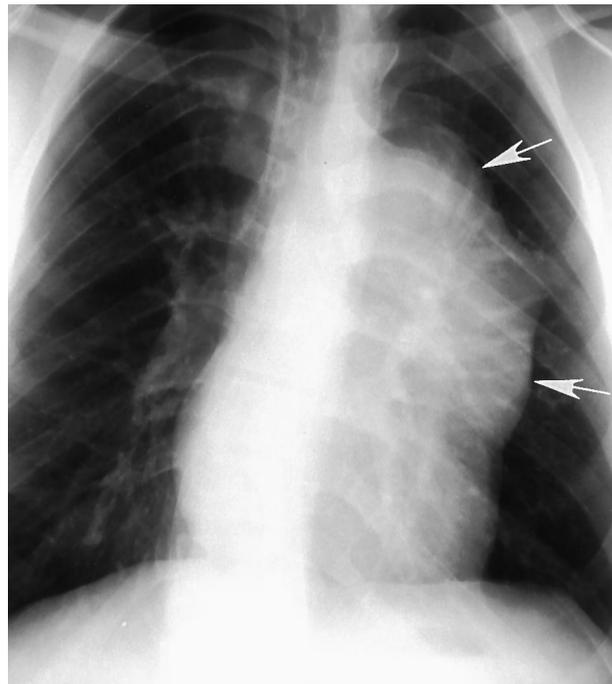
PA chest radiograph in a 19-year-old female subject with chest pain. Large B-cell NHL manifests as a 6×11-cm lobulated left anterior mediastinal mass (arrows).
